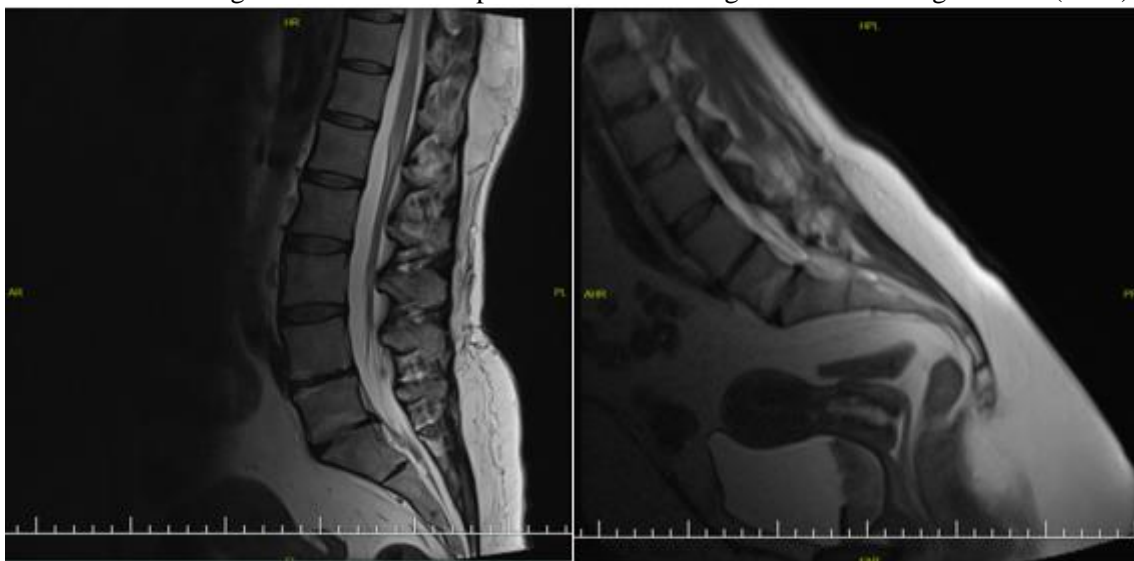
First case's lumbar MRI image
